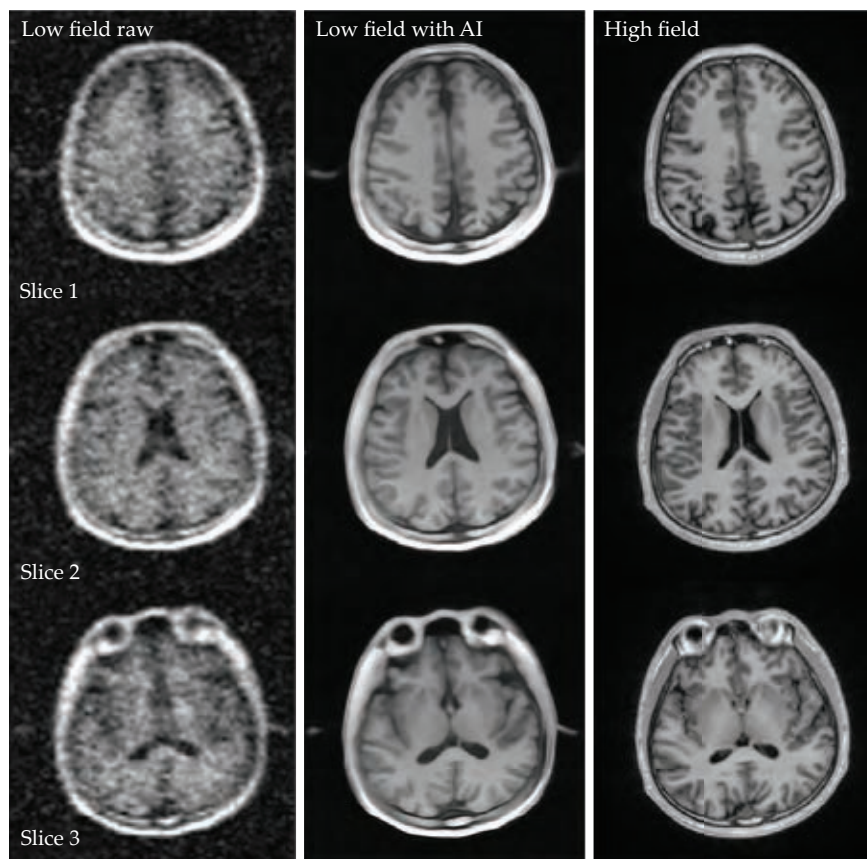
ARTIFICIAL INTELLIGENCE (AI) can reduce the noise and improve the spatial resolution of MRI. The left column shows image slices of a healthy human brain collected by a prototype 0.05 T scanner. The middle column shows the same images corrected with an AI deep-learning algorithm, and the right column shows results from a conventional 3 T scanner. Although some details are sharper in the high-field instrument's images, the AI-reconstructed images show many of the same anatomical features. (Adapted from ref. 2.)
